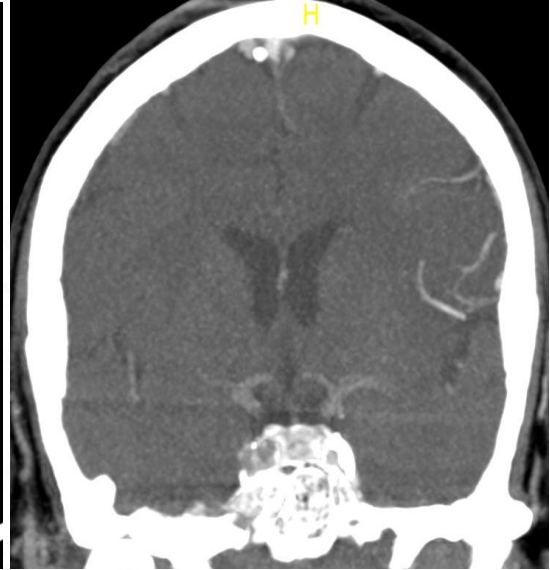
Coronal CT MIP Art. Del. phase showing Poor collateral score (mASITN/SIR 1)
